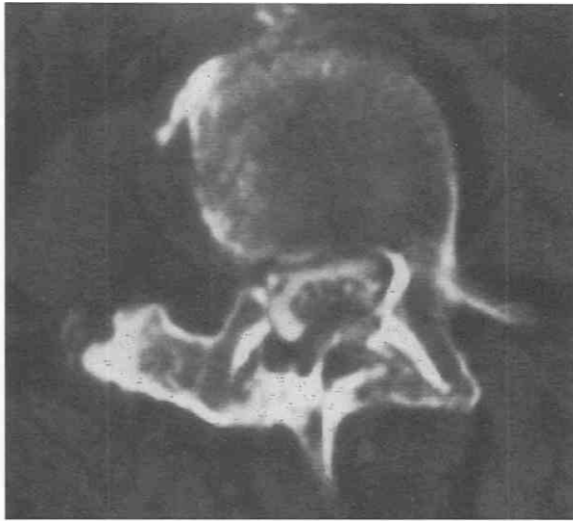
Postoperative bone overgrowth. Postmyelogram CT scan shows severe hypertrophy of posterior elements compressing the spinal canal.
